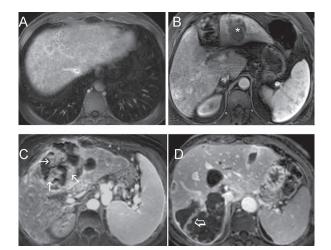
Axial, gadolinium-enhanced, T1-weighted MR images, with examples of HCC not suitable for accurate assessment with mRECIST: In tumors which are diffusely infiltrating (A), or hypovascular (asterisk, B), prior to treatment, measurement of clearly defined, arterially enhancing components may be impossible. Moreover, the unidimensional measurement of the largest enhancing residual component, may not reliably predict the extent of TACE-induced necrosis in tumors with multiple, irregular and discontinuous islets of viable tissue (arrows, C), or when the residual tumor has a bizarre, elongated shape (open arrow, D).
